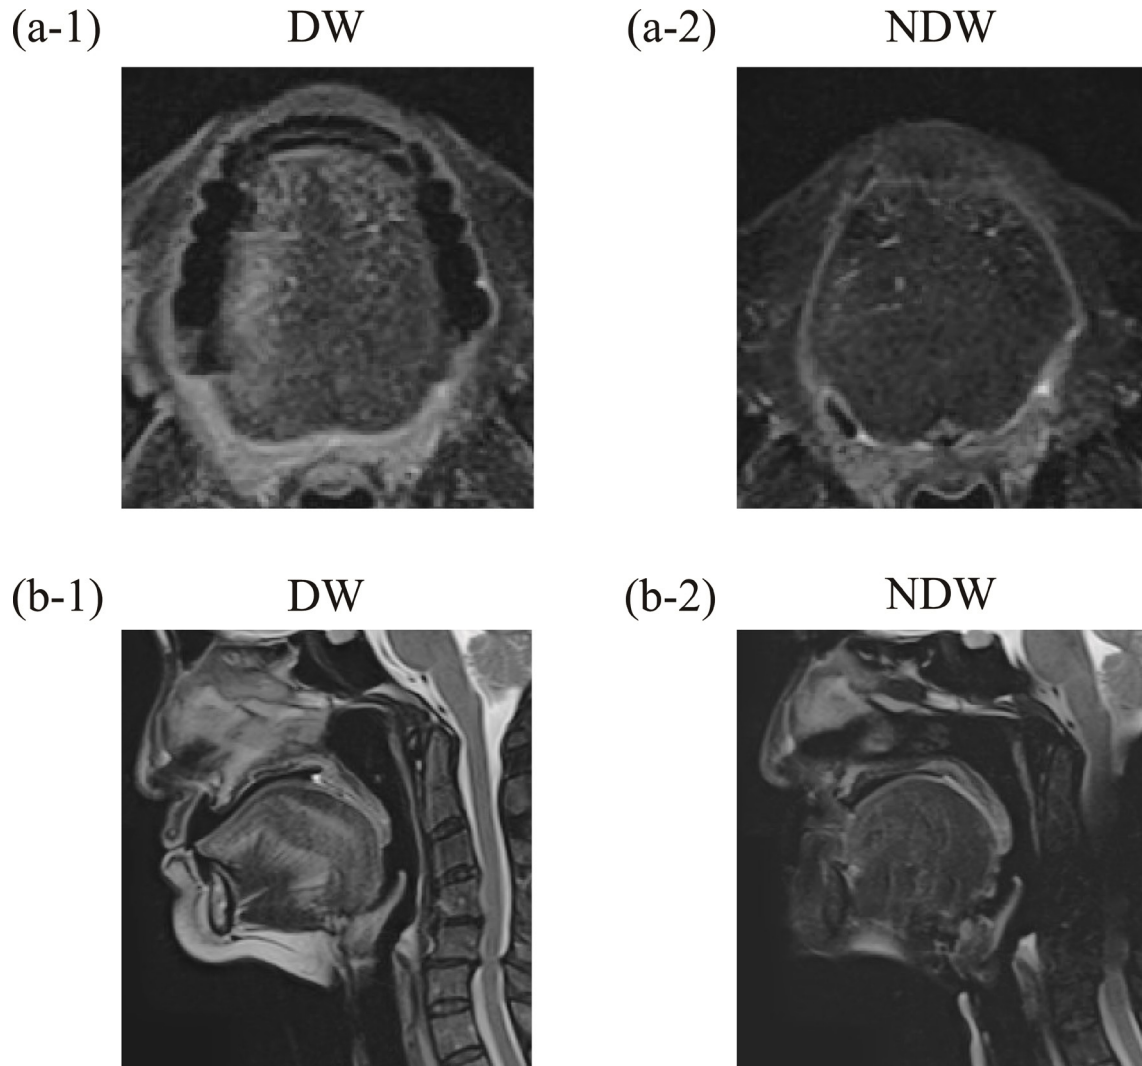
Magnetic resonance imaging
